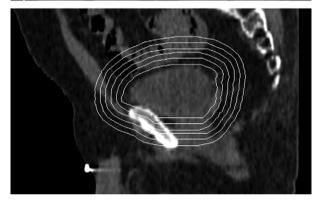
Planning CT scan in axial, coronal and sagittal planes with six isotropic PTV margins.
